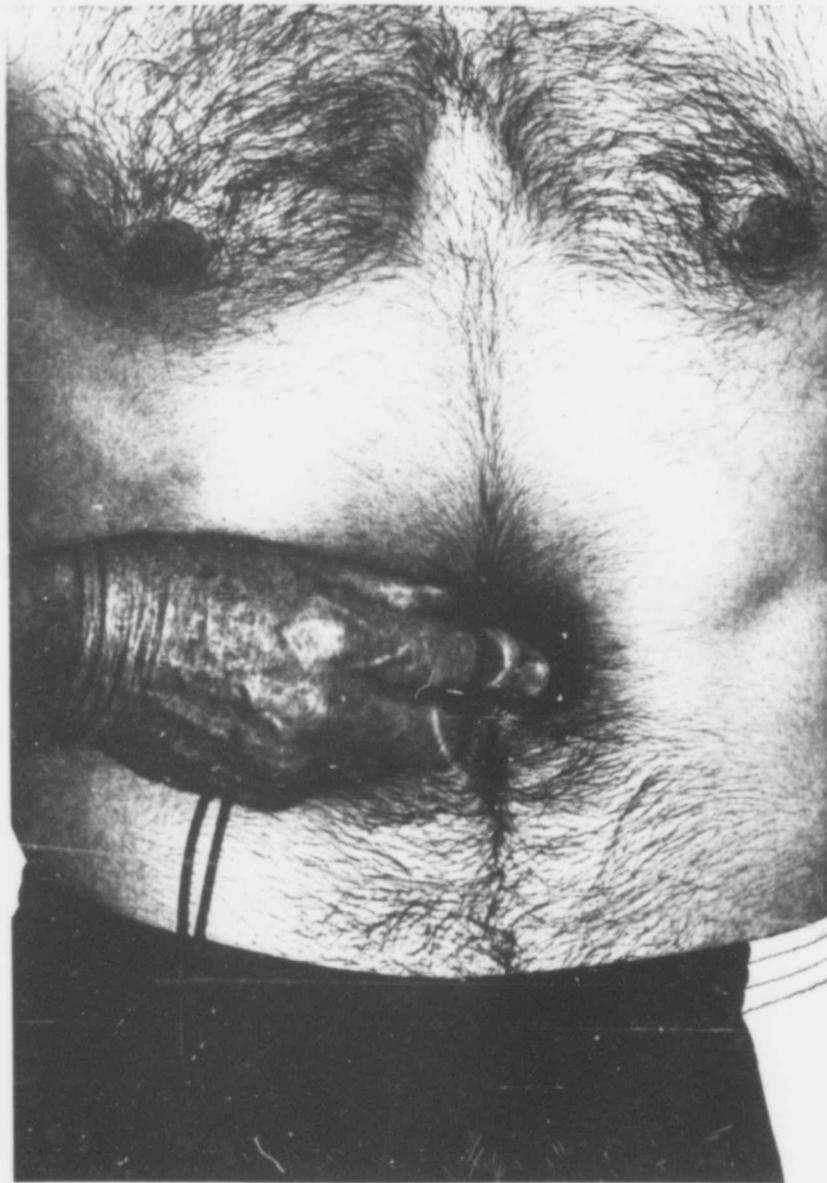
Placement of the Doppler ultrasound transducer for the inferior *vena cava*.
